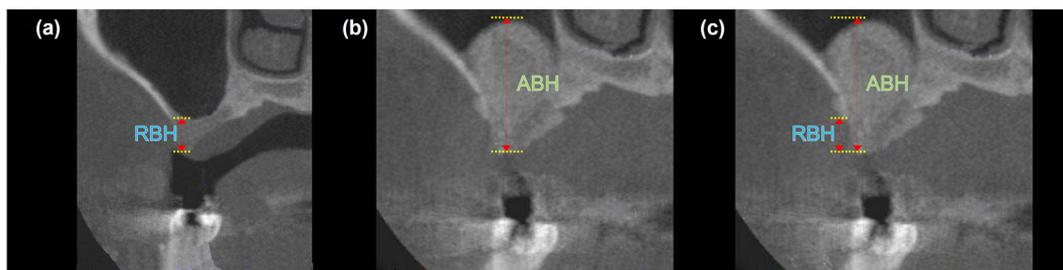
Cone-beam computed tomography images. (a) Preoperative image. (b) Image taken six months after bone grafting. (c) Standardized calculation of RBH and ABH. RBH, residual bone height; ABH, augmented bone height.
